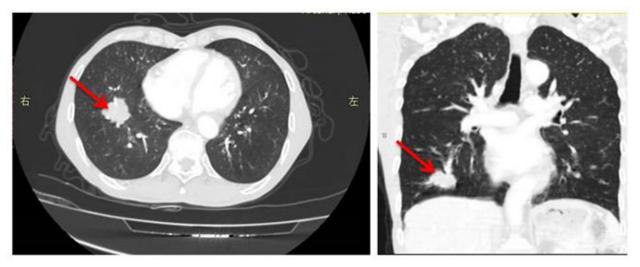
Chest enhanced contrast CT scan shows a lobulated tumor measuring 35mm*31mm in the inferior lobe of right lung
